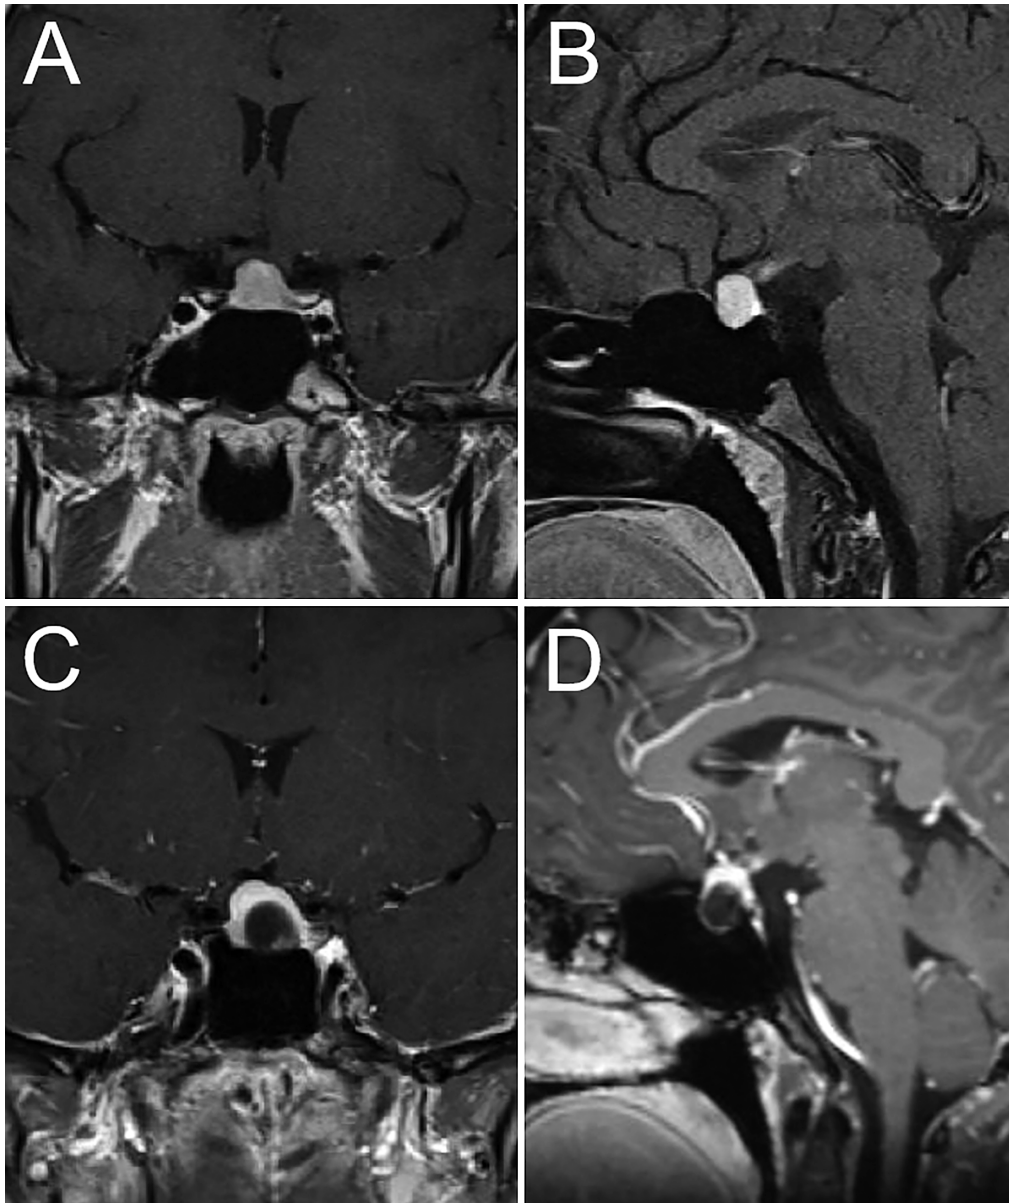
MRI showing homogenous pituitary gland enhancement which is in keeping with physiologic enlargement with 11 mm in pituitary height (A and B). Current MRI images after nine years from the initial scan, which revealed a less enhanced sellar mass that is consistent with pituitary adenoma compressing the pituitary gland upward (C, D).
